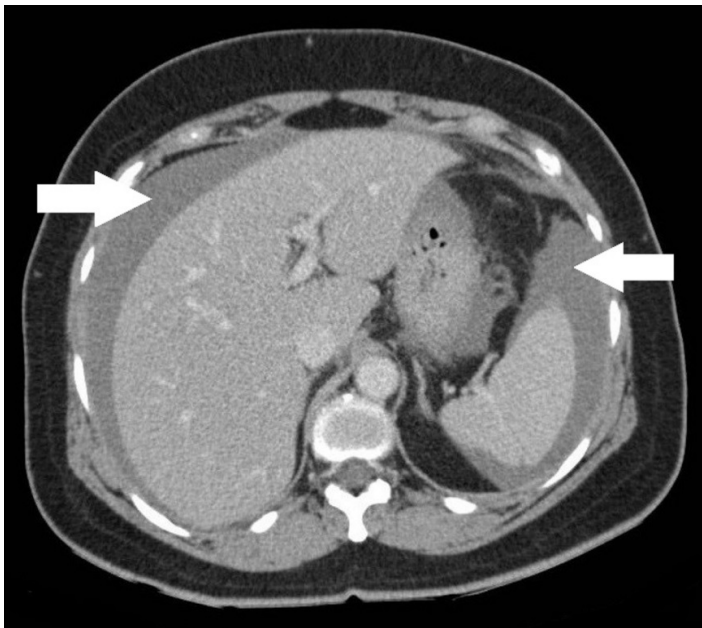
Computed tomography of the abdomen and pelvis showing free intra-abdominal fluid as indicated by the white arrows, later determined to be a gastrointestinal stromal tumor.
